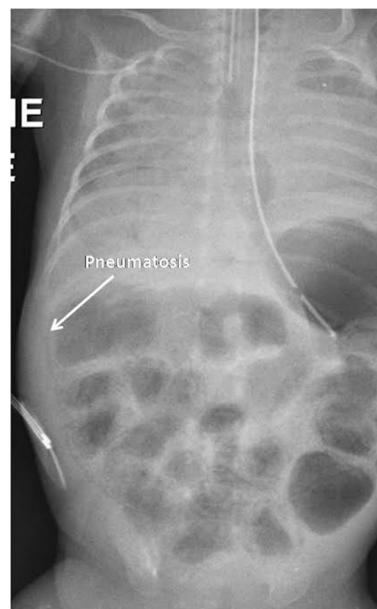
Pneumatosis on plain abdominal radiography.
